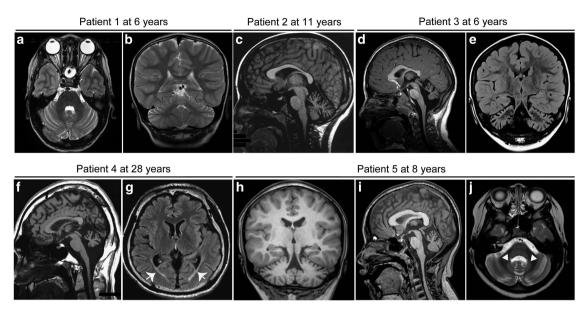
Brain magnetic resonance imaging (MRI) of patients. (a, j) T2-weighted axial images, (b) T2-weighted coronal image, (c, d, f, i) T1-weighted sagittal images, (e) fluid-attenuated inversion recovery (FLAIR) coronal and (g) axial images and (h) T1-weighted coronal image. (a, b) Patient 1 at 6 years of age, (c) patient 2 at 11 years, (d, e) patient 3 at 6 years, (f, g) patient 4 at 28 years and (h, i, j) patient 5 at 8 years. Cerebellar atrophy was observed in all patients (a-f, h, i). In patient 4, a slightly high intensity area surrounding the lateral ventricles bilaterally was observed on FLAIR images (arrows). In patient 5, a hyperintense dentate nucleus was observed on T2-weighted images (arrowheads).
